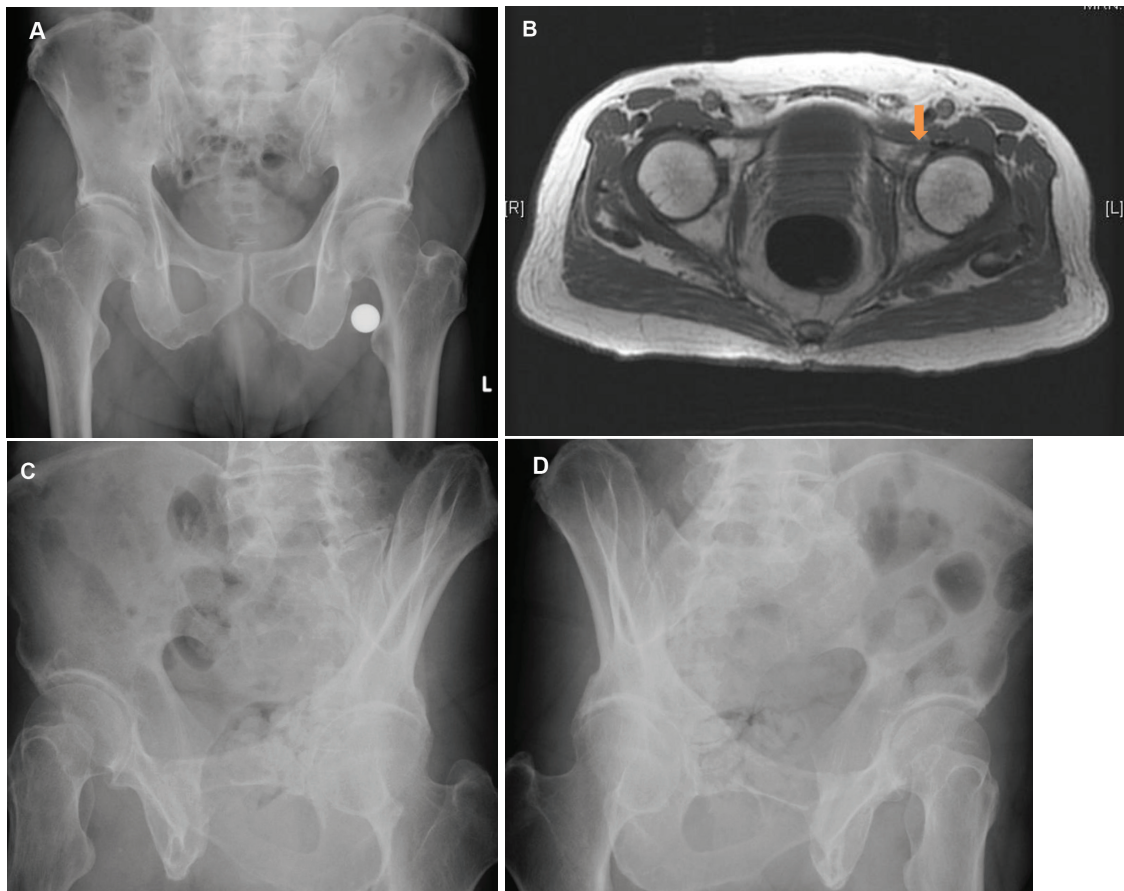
Imaging of Patient 1. In A, no fracture is revealed in anteroposterior pelvis X-ray of patient performed on the day of admission. In B, MRI scan of the pelvis of patient performed 2 days after admission, showing a non-displaced fracture of the anterior column of the left acetabulum. In C and D, Judet's view of the pelvis of patient performed 1 month after MRI of his pelvis. No definite fracture line was seen.
